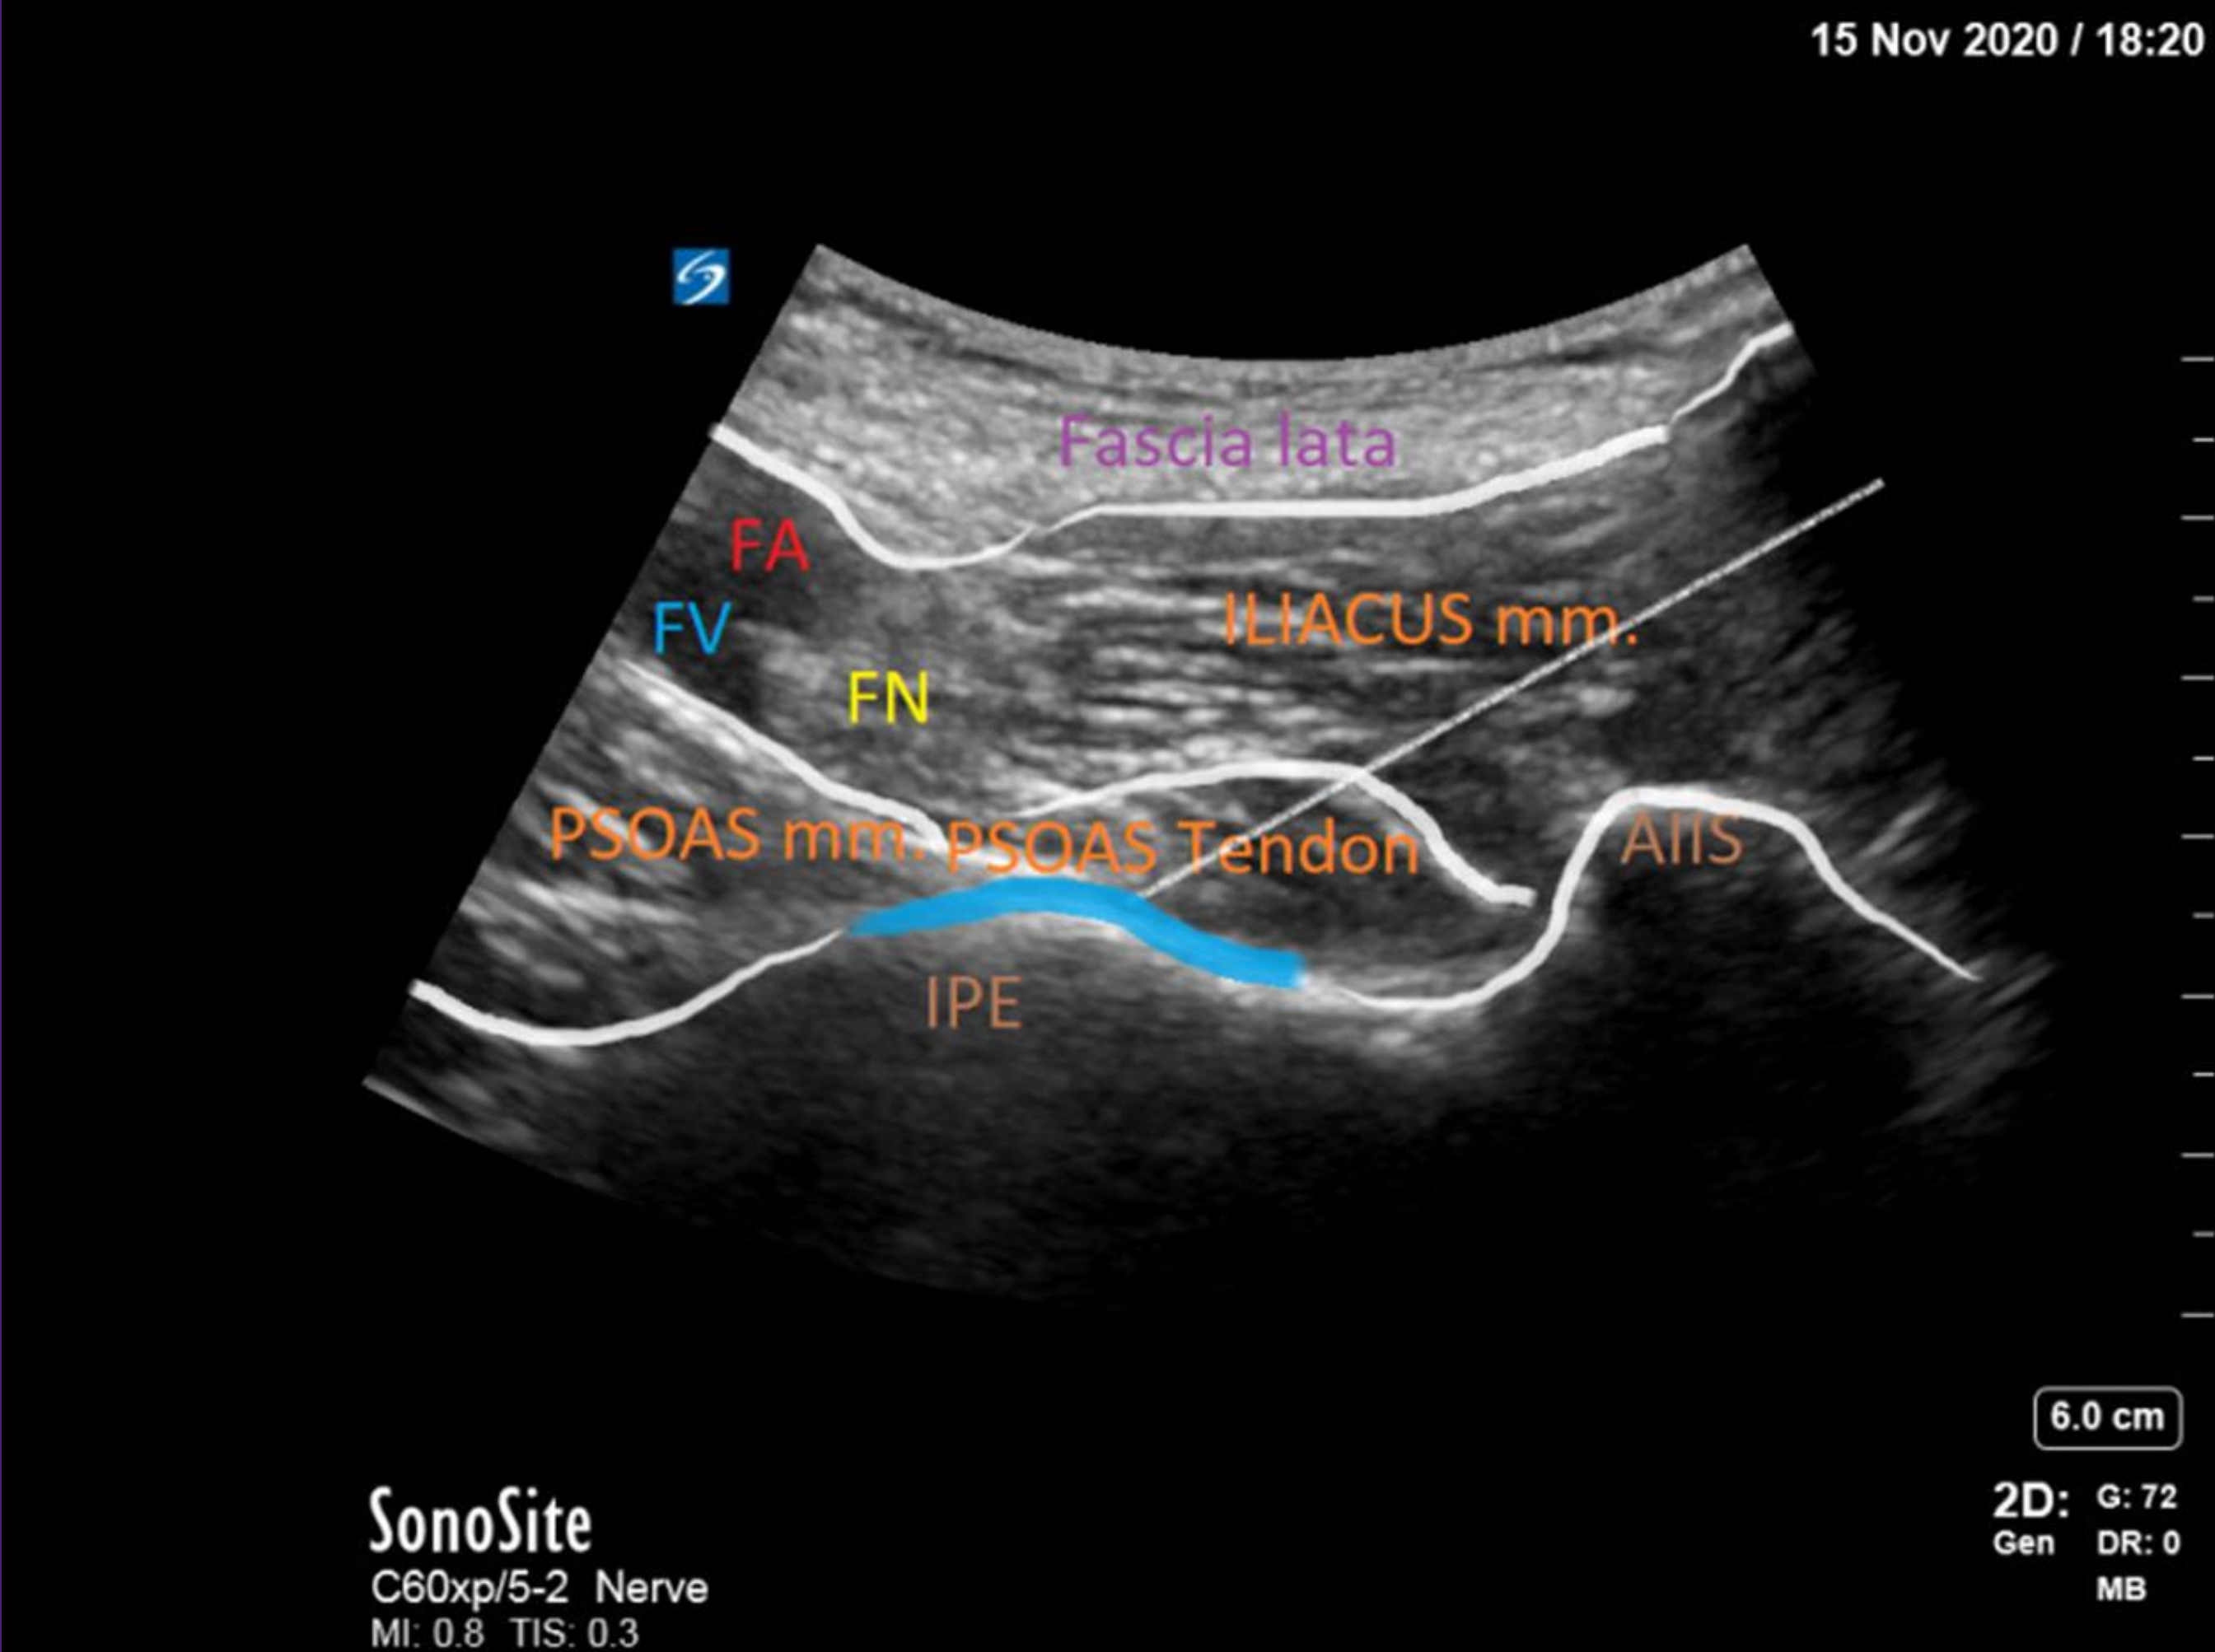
Ultrasound Image of Pericapsular Nerve Group Block. Identification of the anterior inferior iliac spine and iliopubic eminence is achieved and local anesthetic is injected superficial to the iliopubic eminence to lift the psoas tendon to anesthetize the proximal articular branches and spare motor function⁶
